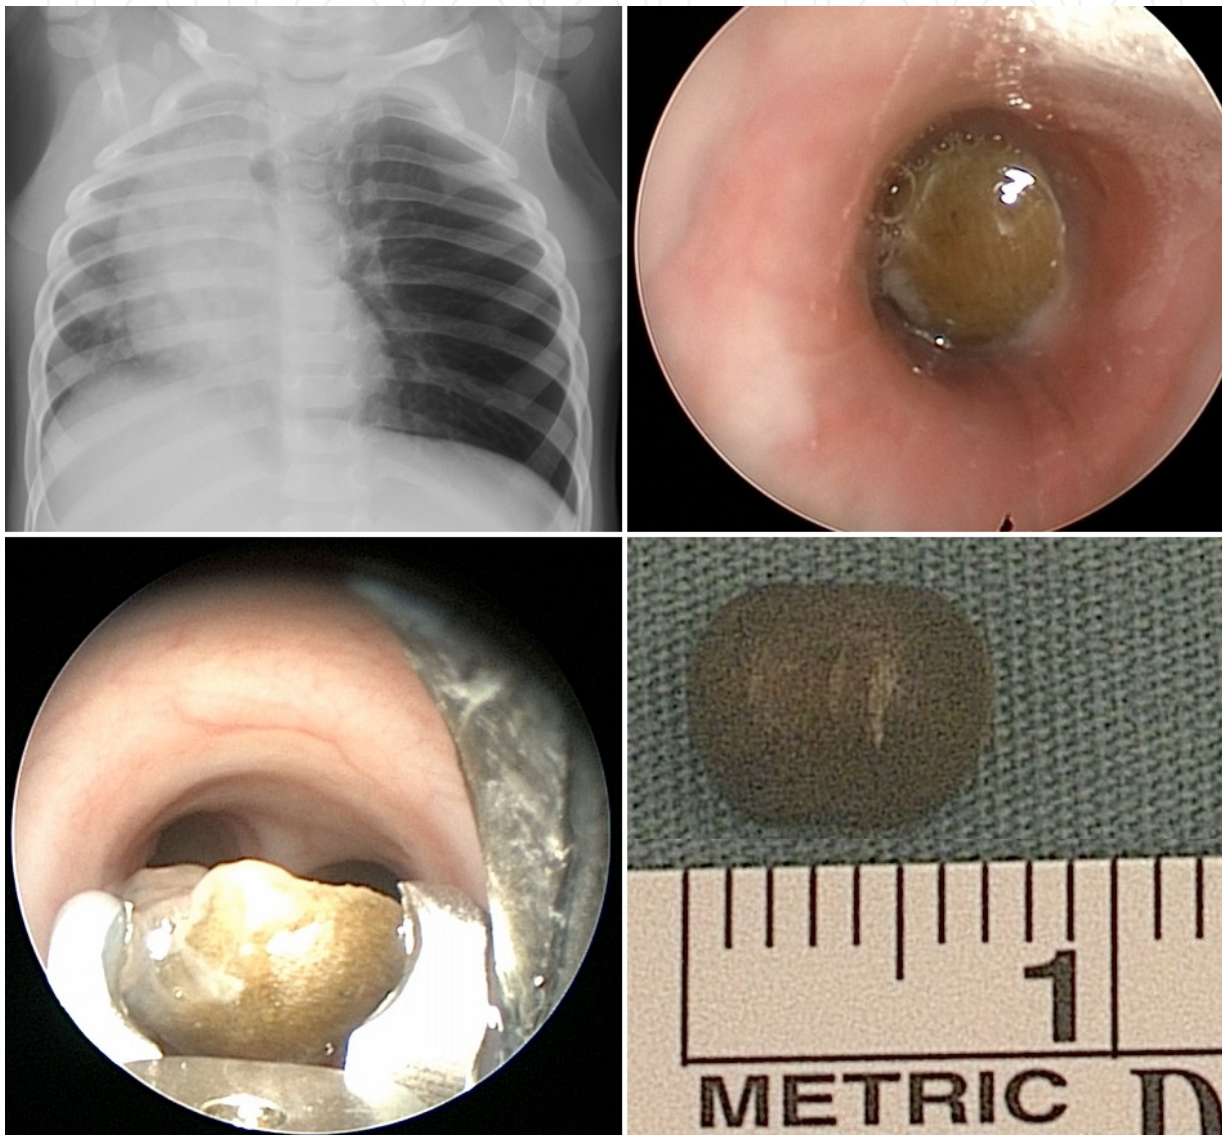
A 13-month old presented to the emergency room with wheezing and coughing. The child had reportedly put something into its mouth earlier that day. An A-P plain film showed hyperinflation of the left lung with right-sided mediastinal shift. There was no radiopaque foreign body noted on the plain film. Direct laryngoscopy with rigid bronchoscopy revealed a left mainstem foreign body, consistent with half of a wooden bead that was removed with an endoscopic optical forceps.
